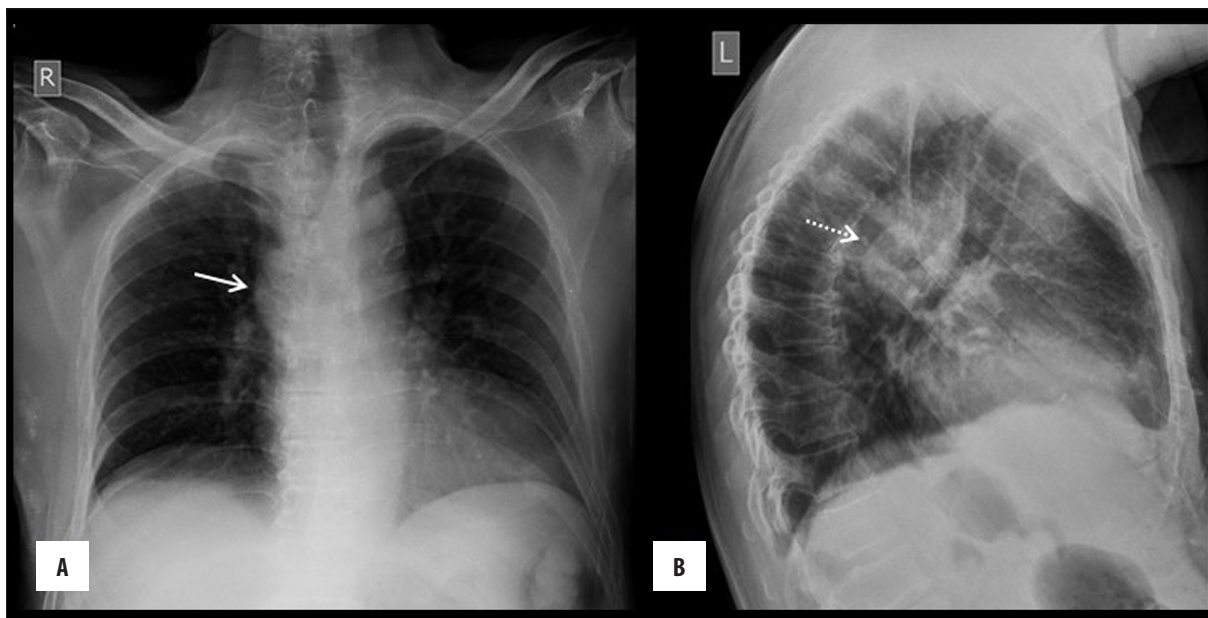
(A) Frontal chest radiograph showed prominence in the region of ascending aorta mimicking an aneurysm (solid arrow). (B) Left lateral radiograph showed radio dense lesion inferior to arch of aorta with mass effect on trachea (dotted arrow).
